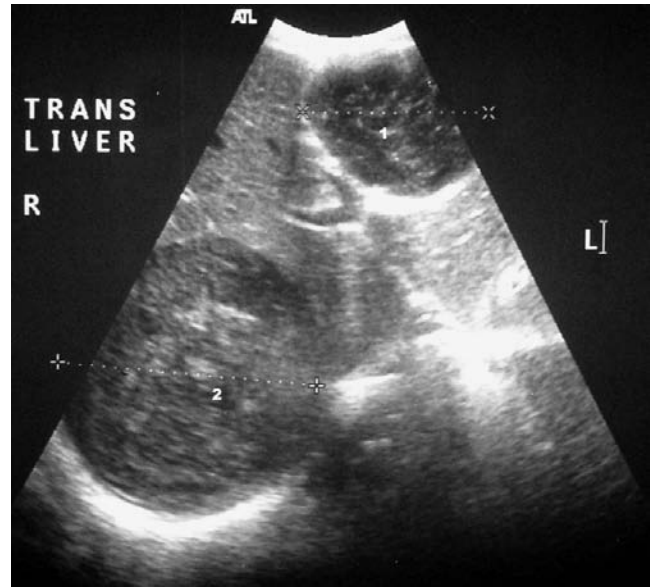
Axial ultrasound scan of the liver demonstrating two mixed echogenicity lesions in the liver involving segments 3 and 4B of the left lobe (1) and segments 5 and 6 of the right lobe (2), interpreted as abscesses.
